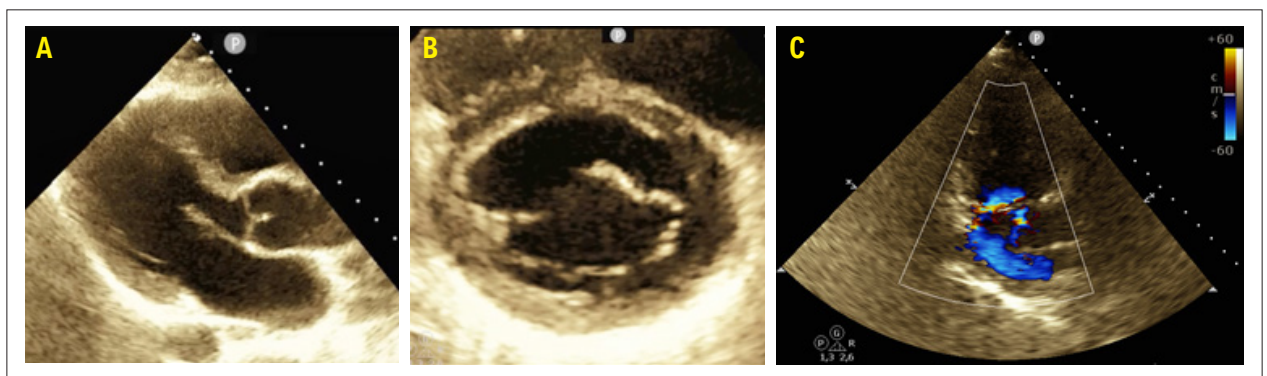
Posterior mitral leaflet hypoplasia on transthoracic echocardiography: (A) parasternal long-axis view demonstrating an anterior leaflet disproportionately elongated relative to the posterior leaflet; (B) mitral valve short-axis view demonstrating absence of stenosis; (C) apical two-chamber view demonstrating eccentric jet.
